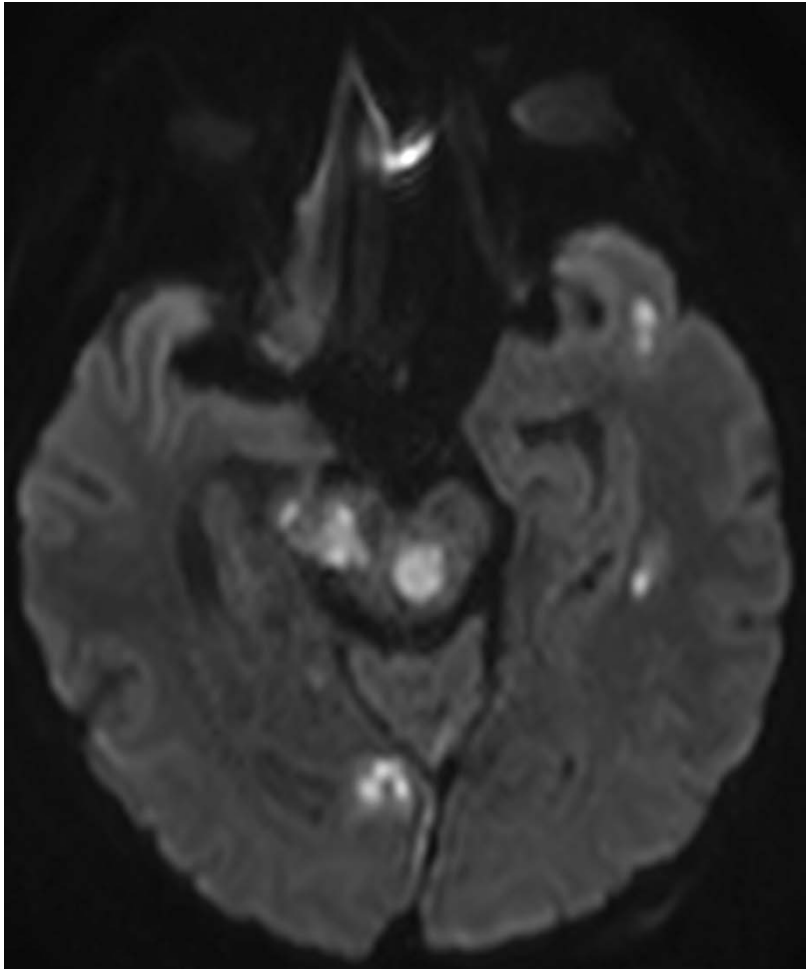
Follow up MRI revealing enlarged existing lesions and new lesions with signal restriction - Diffusion Weighted Image (DWI)
